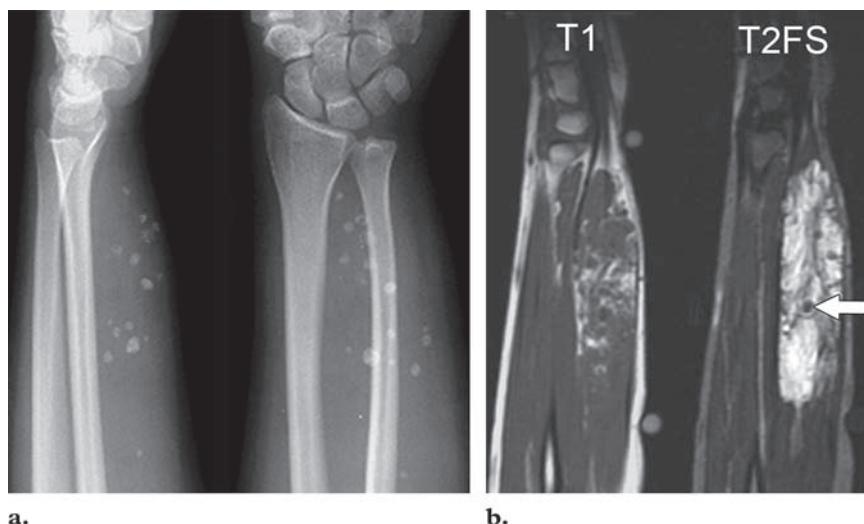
Vascular malformation with phleboliths. (a) Lateral (left) and posteroanterior (right) radiographs show a hemangioma in the volar compartment of the forearm. The hemangioma contains multiple calcified phleboliths. (b) Sagittal T1-weighted (left) and T2-weighted fat-saturated (right) magnetic resonance (MR) images show the serpentine high T2 signal intensity characteristic of a hemangioma. There is also interspersed fat and rounded low-signal-intensity areas (arrow), which are related to the phleboliths.
